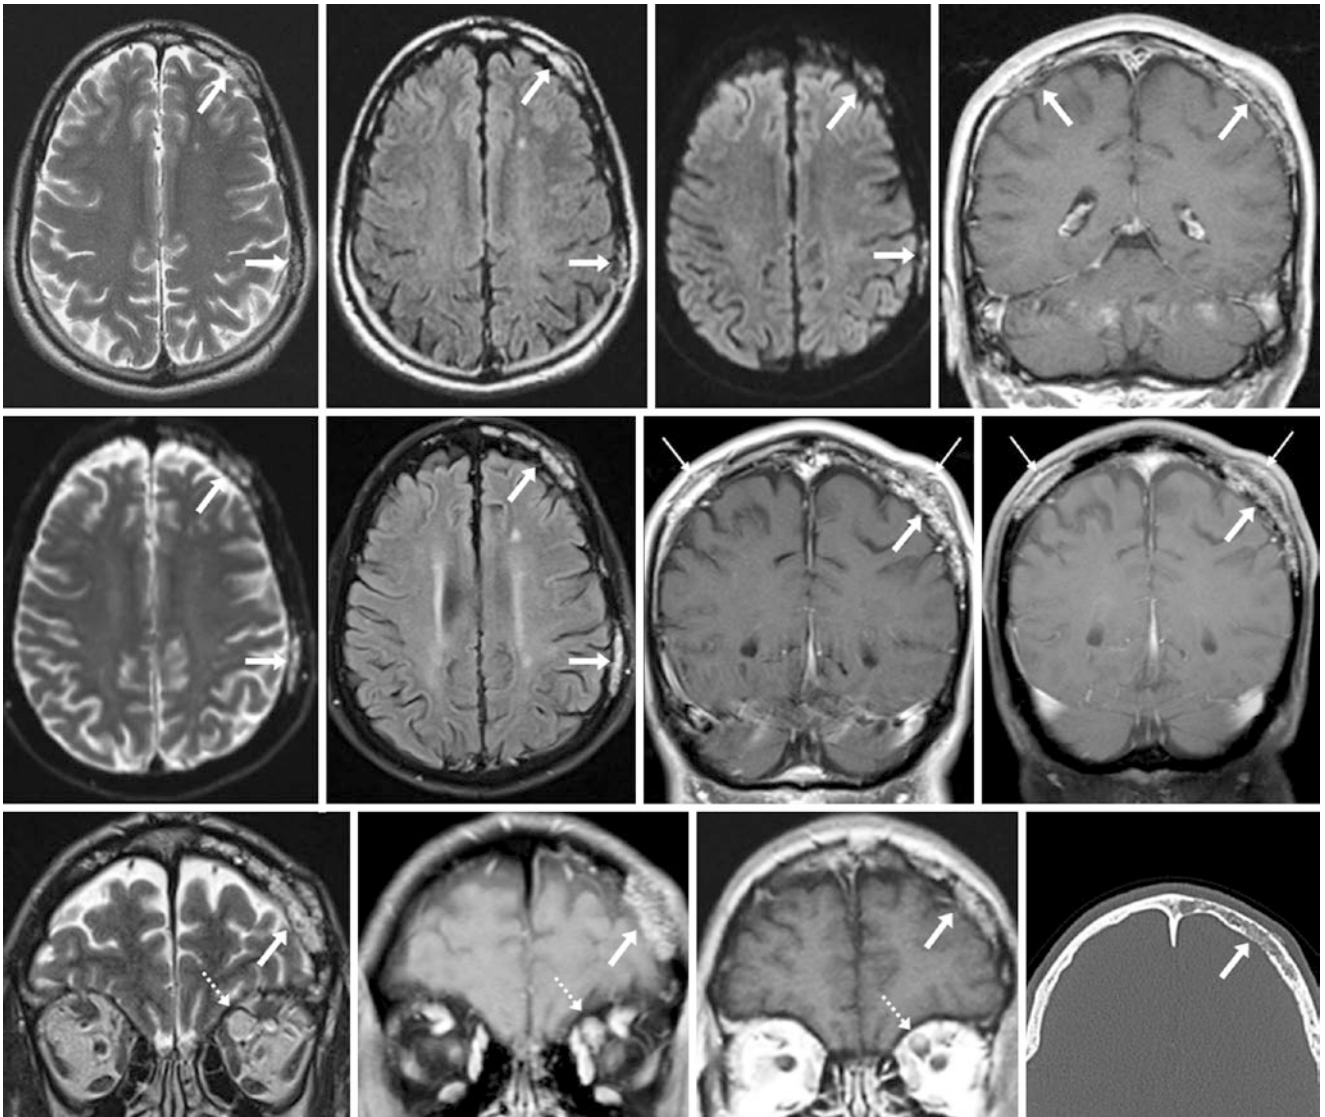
A 48 year old with many hemangiomas (angiomas). *Top row*: multiple calvarial bright lesions (*arrows*) were noted on T2WI (*left*), FLAIR (*left middle*) DWI (*right middle*), and postcontrast T1WI (*right*). *Middle row*: 10 years later, these were unchanged on T2WI (*left*) and FLAIR (*left middle*), and enhanced on postcontrast coronal T1WI initially (*right middle*) and minutes later (*right*), typifying
